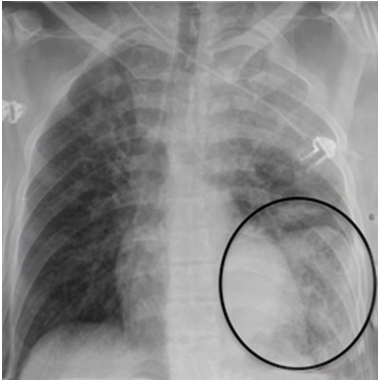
Chest X-ray findings in blunt diaphragmatic lesions. This antero-posterior chest X-ray shows viscera herniation in the thoracic cavity (circle) in association with costophrenic sulcus obliteration and distorted diaphragmatic profile.
